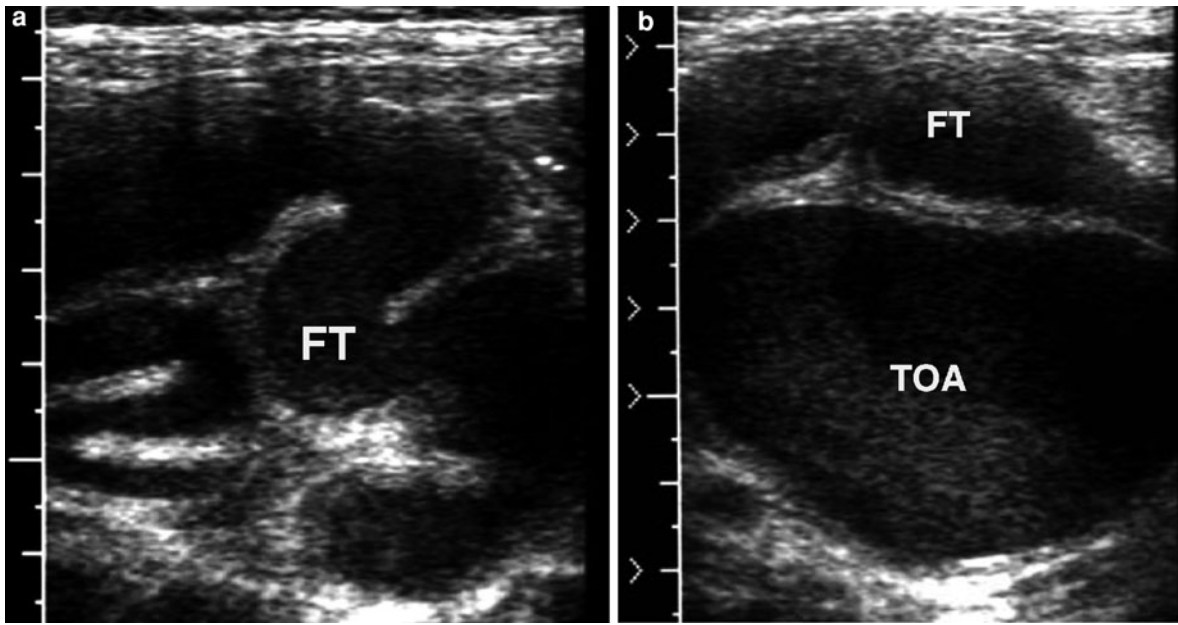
a, b Pelvic inflammatory disease mimicking acute appendicitis. a is transverse sonogram of right lower quadrant demonstrating pyosalpinx with echogenic pus within dilated
